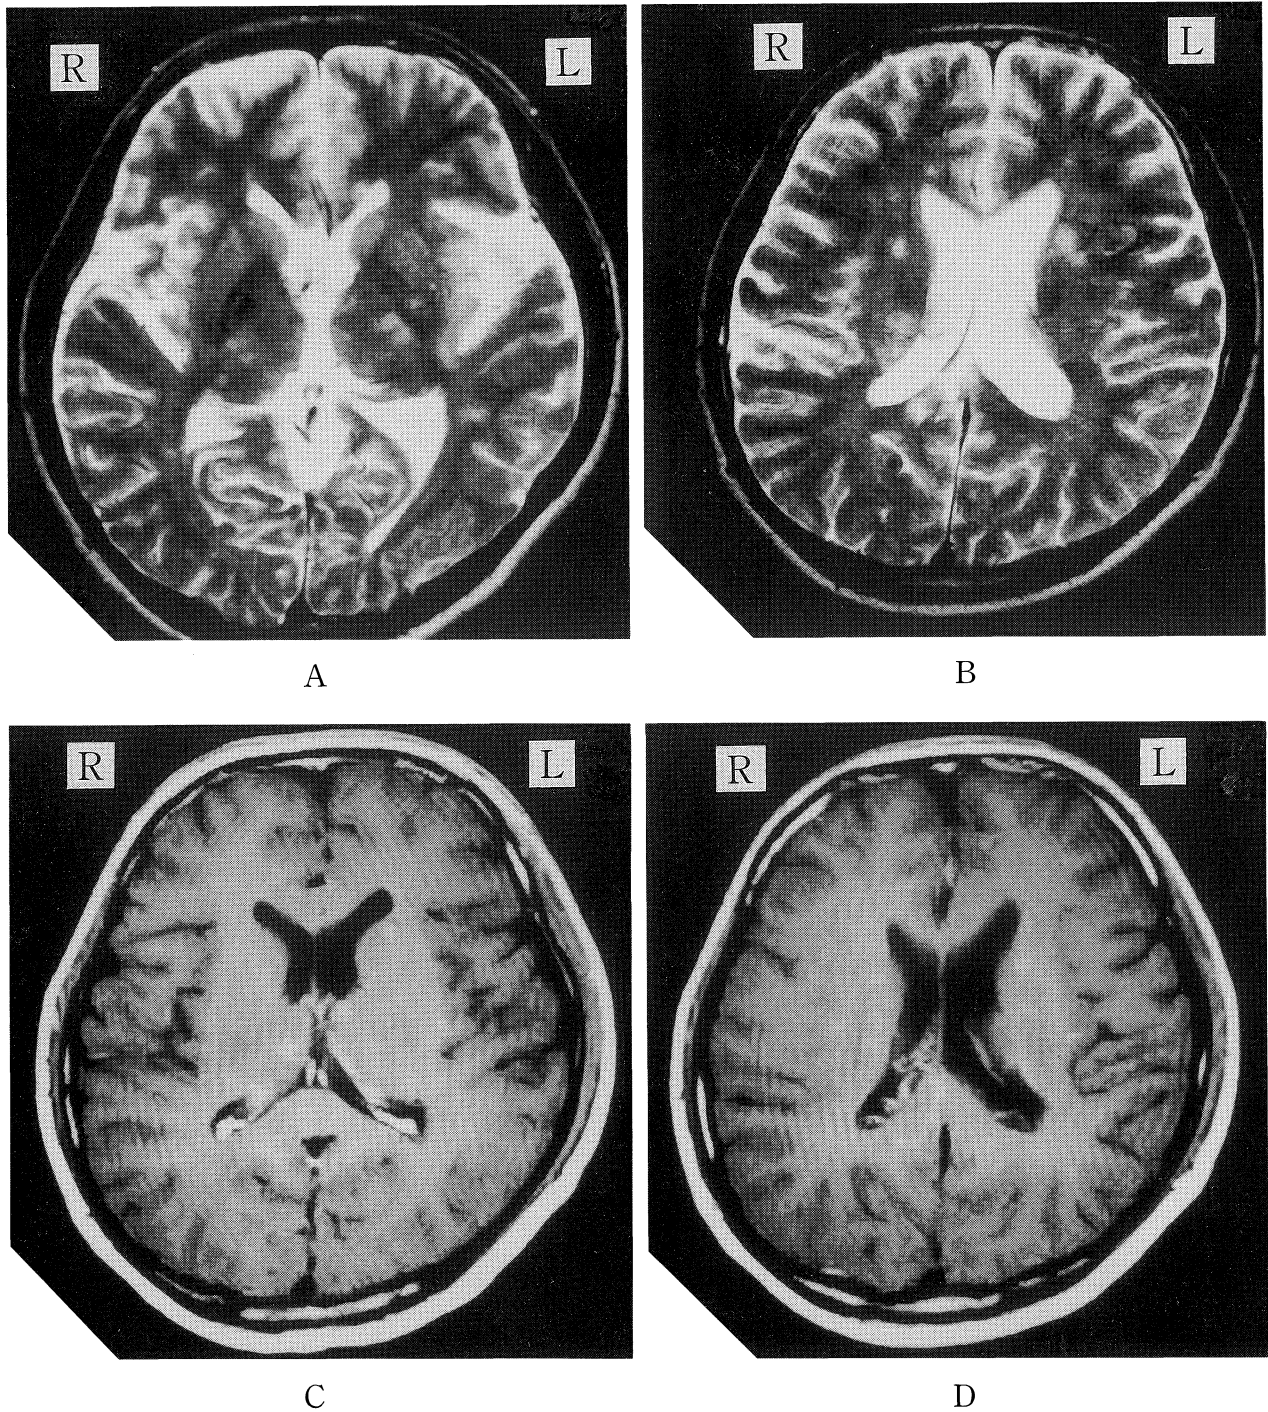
Cranial MRI (1.5 tesla) before corticosteroid treatment. T2-weighted images (TR: 2,300, TE: 90) show multiple high-intensity lesions in the internal capsules, the basal ganglia (A) and periventricular white matter (B). These lesions were shown as iso-intensity on enhanced T1-weighted images (TR: 600, TE: 15) (C, D) and several lesions were enhanced.
